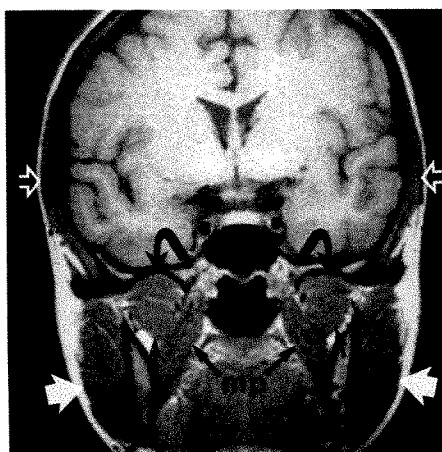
Normal muscles of mastication in 32-year-old female volunteer with medium build. Closed-mouth coronal 3-mm-thick MR image, 800/20, with head coil shows normal temporalis (open arrows), masseters (solid white arrows), and medial pterygoids (mp), representing the muscles of jaw closure. Superior (curved arrows) and inferior (small black arrows) bellies of lateral pterygoids function in mouth opening.
